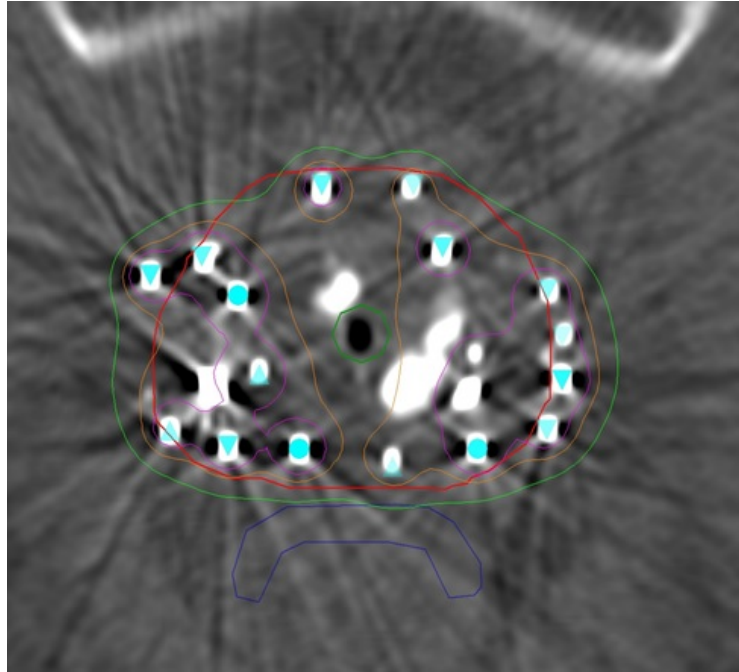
Prostate LDR post-implant CT. The seeds (bright spots) are identified to calculate the dose to the prostate (red), urethra (green) and rectum (blue). Here, the prostate was defined on MRI and the contour transferred to the CT images, due to the difficulty of observing the prostate on the CT.
